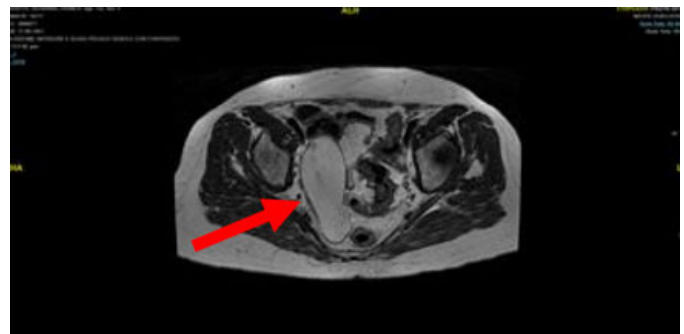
MRI scan confirming thickening of the appendix.
